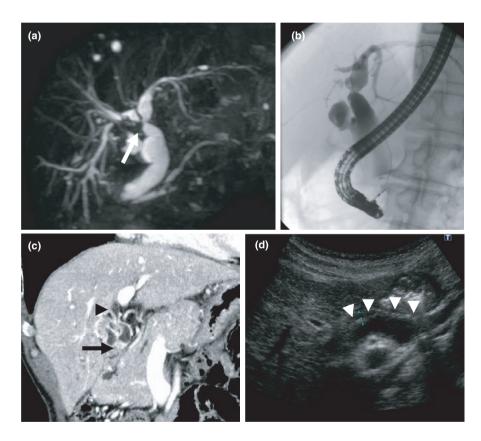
Imaging findings of the bile duct before the second surgery. A, Magnetic resonance cholangiopancreatography revealed stenosis of the bile duct of the hepatic hilum, especially the right hepatic duct (white arrow). B, Endoscopic retrograde cholangiopancreatography demonstrated obstruction of the right hepatic duct and extensive irregularities in the extrahepatic bile duct wall. C, Contrast-enhanced CT (coronal view) demonstrated enhanced wall thickening of the extrahepatic bile duct from the upper margin of the pancreas (arrow) to the root of the left hepatic duct (arrowhead). CT, computed tomography. D, Ultrasonography revealed the wall thickening of dilated extrahepatic bile duct (white arrowhead)
